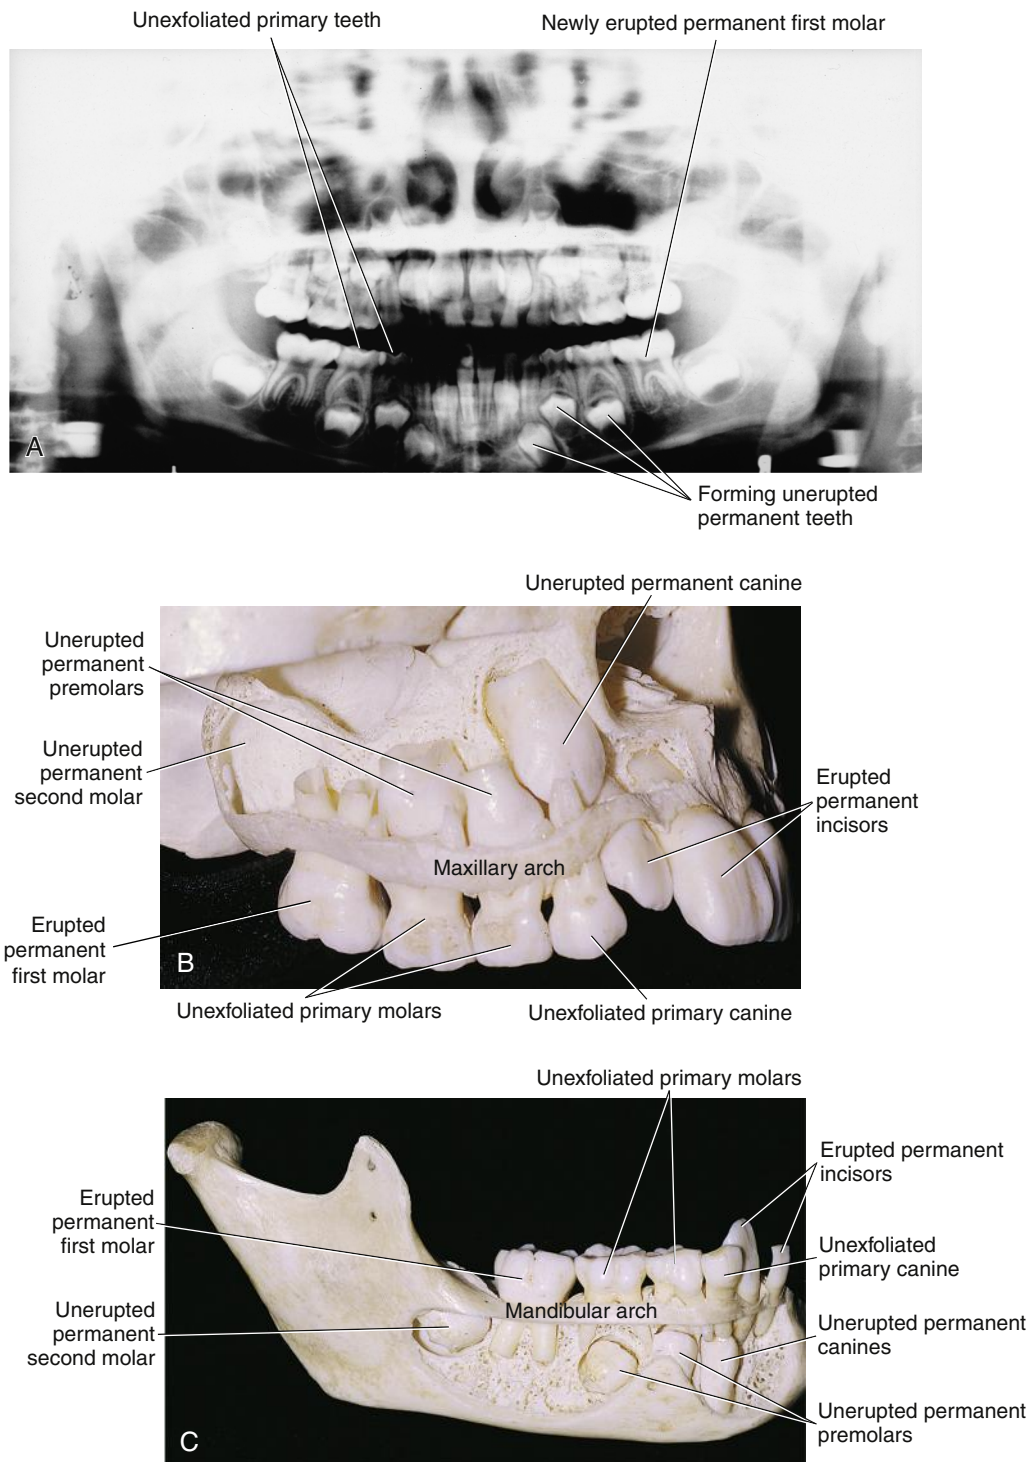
Mixed dentition with primary teeth being shed and the permanent dentition erupting within the jaws of each arch. A, Panoramic radiograph. B and C, Maxilla and mandible with a section of facial cortical plate removed. (Courtesy of Margaret J. Fehrenbach, RDH, MS.)
